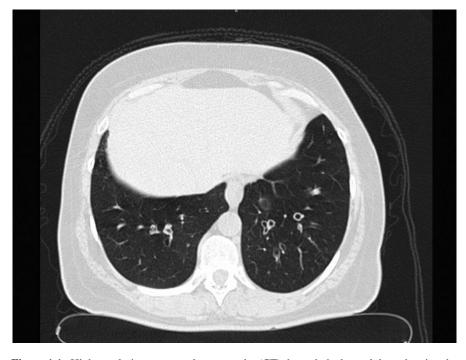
High-resolution computed tomography (CT) through the lower lobes, showing the classic signet ring sign (dilated bronchus with adjacent pulmonary artery of normal size) seen in established bronchiectasis.
